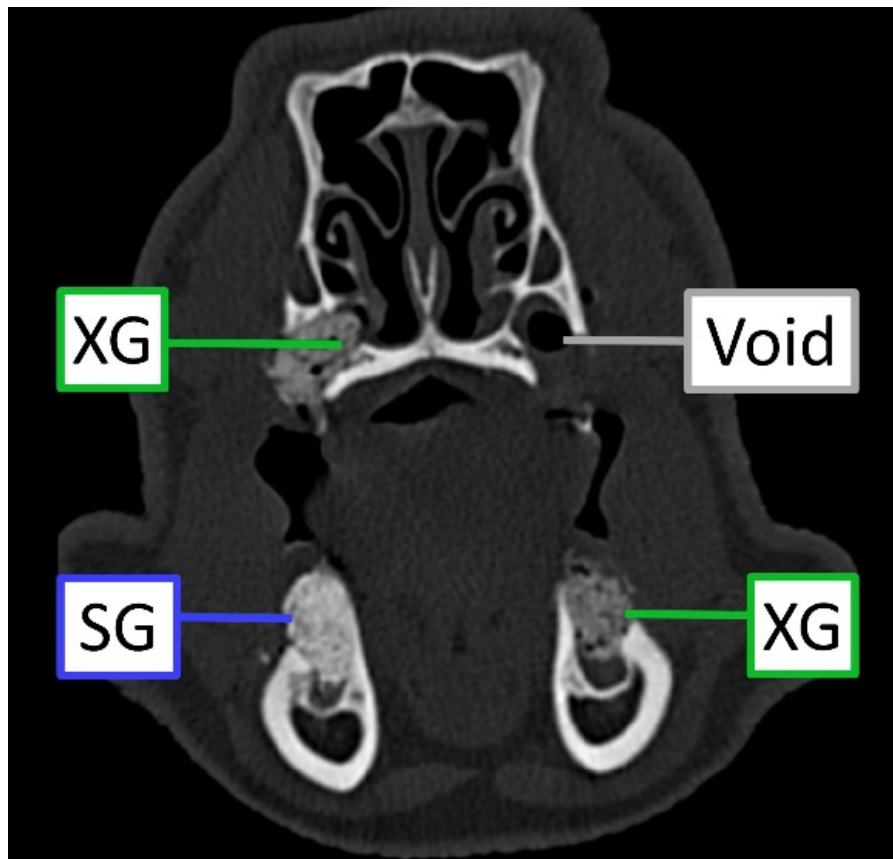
Coronal slice of a CT scan showing four premolar grafted defects.
